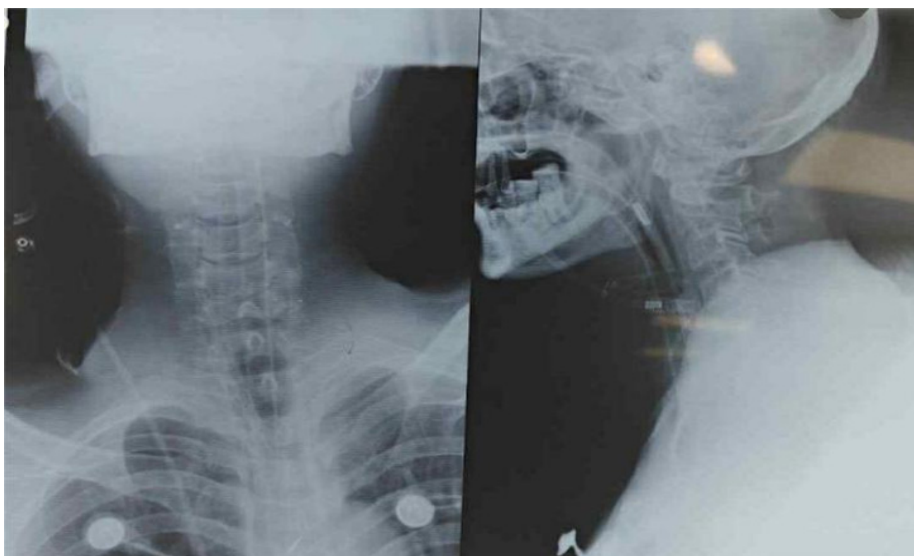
Post procedure chest radiograph confirming complete removal of the foreign body
